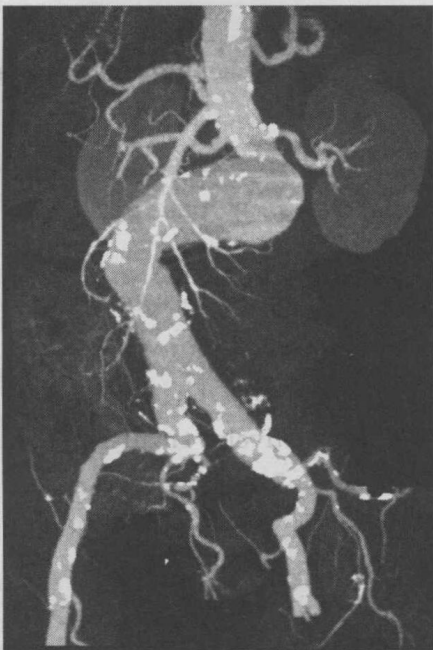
CT angiography MIP projection of abdominal aortic aneurysm. Bone (vertebral column, pelvis) has been edited away
